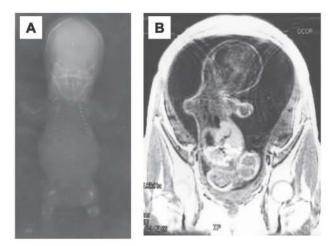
A. Roentgenogram of TD. Note the shortness of ribs, flattened and H-shaped vertebral bodies, and well-ossified skull. B. MRI examination of HPH. Note extremely short limbs. C. Roentgenogram of HPH. Note absence of ossification in vault with abnormally short ribs.
